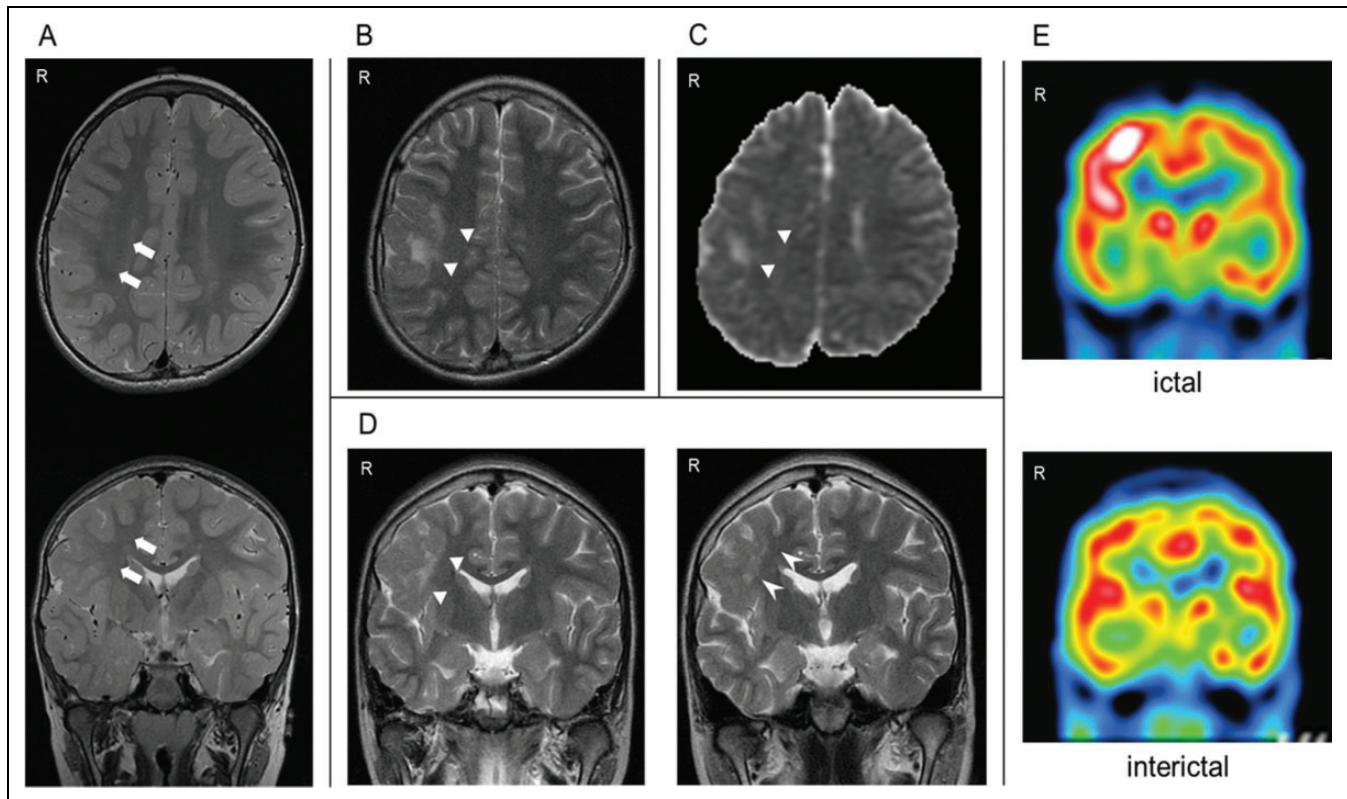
A, At the age of 3 years, a T2-weighted MRI scan showed focal cortical dysplasia in the right centroparietal region (↔). There were no high signal intensity lesions at this time. B, On day 2 after admission, a T2-weighted MRI image showed a high signal intensity lesion (▲) adjacent to the focal cortical dysplasia lesion. C, Apparent diffusion coefficient mapping also showed a high signal intensity lesion in the same region. D, The high signal intensity lesion (▲) was located close to the right insular cortex (left). On day 69, the high signal intensity lesion had diminished in size, and the patient's cluster seizures had improved (right). E, On day 27, ictal ^{99m}Tc -ethyl cysteinate dimer SPECT detected hyperperfusion in a region containing the high signal intensity lesion seen on MRI, which was located close to the right insular cortex. Interictal ^{99m}Tc -ethyl cysteinate dimer SPECT performed on day 68 did not detect any abnormalities. MRI indicates magnetic resonance imaging; SPECT, single-photon emission computed tomography.
